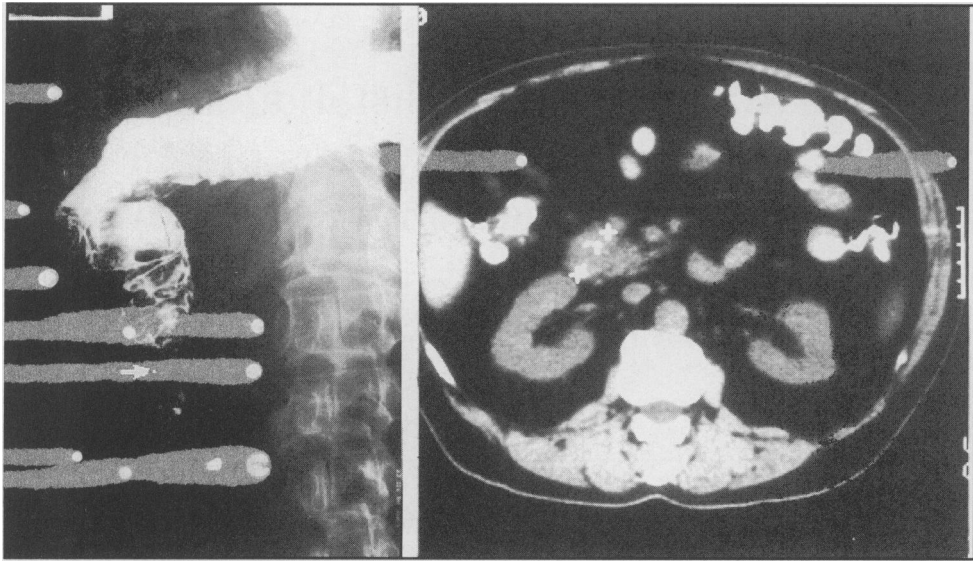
Barium meal and CT scan demonstrating a stricture in the third part of the duodenum (arrow) due to a 4 cm diameter solid lesion (seen between calipers).
